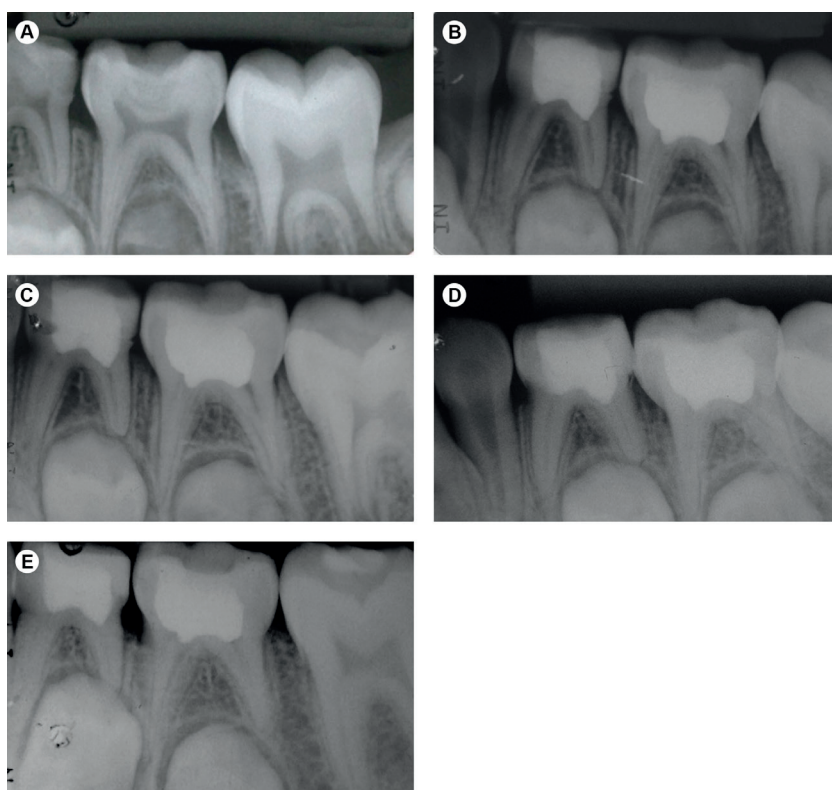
Pulpotomies of primary mandibular left first molar with MTA and second molar with 15.5% Ferric Sulfate (radiographic success). A: Preoperative periapical radiograph of the teeth showing extensive caries lesions, more than two thirds of root lengths, and no signs of periapical lesions; B: 3-month follow-up periapical radiograph showing the pulpotomized teeth; C: 6-month follow-up periapical radiograph suggesting the absence of periapical lesion in the pulpotomized molars; D: 12-month follow-up periapical radiograph suggesting the initial obliteration of the roots and absence of periapical lesion in the pulpotomized molars; E: 18-month follow-up periapical radiograph suggesting the obliteration of the roots and their progressive resorption caused by the eruption of the permanent successors.
